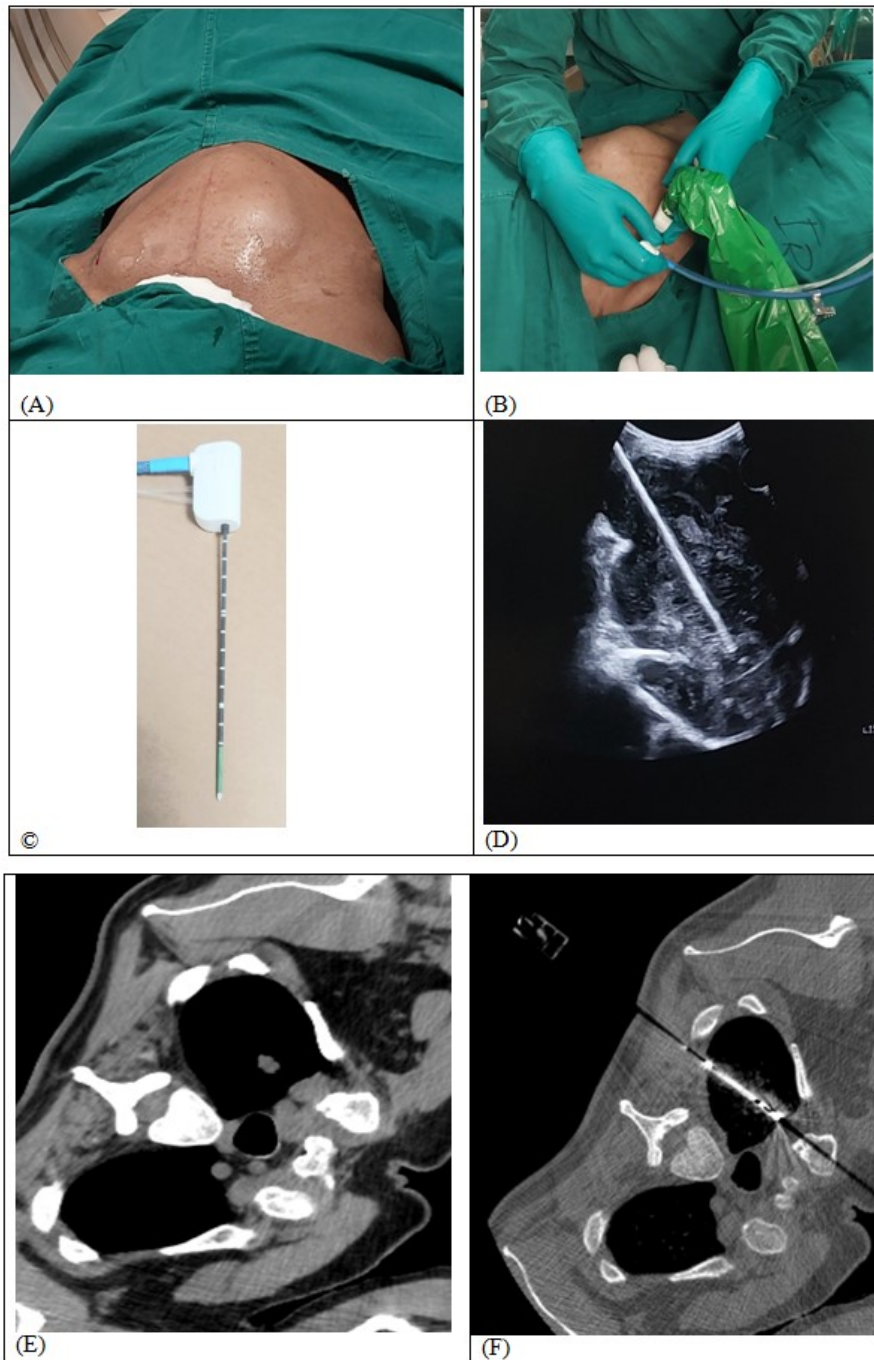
Image – (A) Sterile technique, (B) Guided MWA Antenna/Needle Insertion, (C) MWA Antenna/Needle, (D) USG Guided MWA Antenna/Needle Insertion, (E) Tumor sowing in CT Scan, (F) CT-guided Antenna/Needle placement
